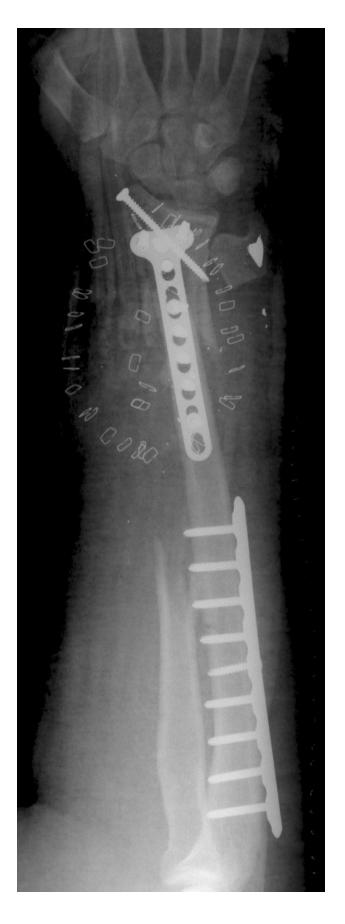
(Left) *Radiograph* (lateral view), *hospital day 3, s/p open reduction and internal fixation. See text for more details.*
